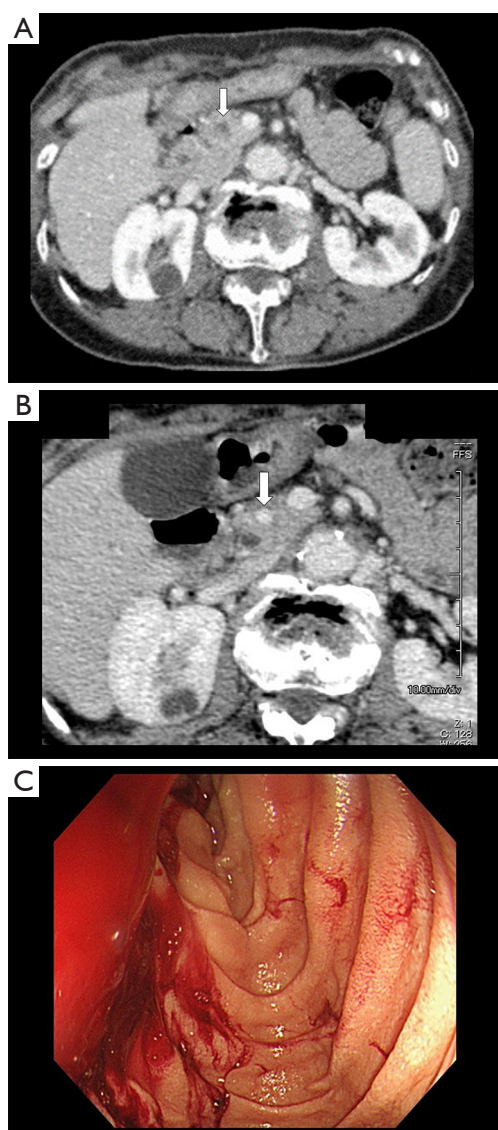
Image findings of the pancreatic metastasis from lung adenocarcinoma. Computed tomography (CT) demonstrated a pancreatic metastasis (white arrow) (A). Six months after administration of osimertinib, CT showed metastatic tumor regression and hemorrhage in the accessory pancreatic duct (white arrow) (B). Upper endoscopy showed active bleeding from the papilla of Vater (C).
